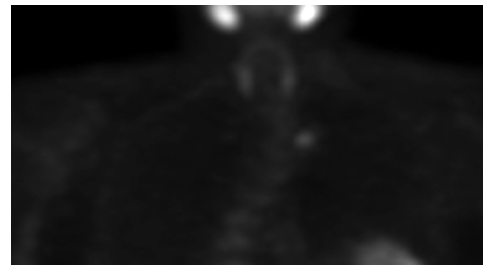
SPECT scan demonstrating aberrant radiotracer uptake in the left superior anterior mediastinum of a persistent primary hyperparathyroid patient. Note the physiologic uptake of radiotracer by normal salivary glands.
